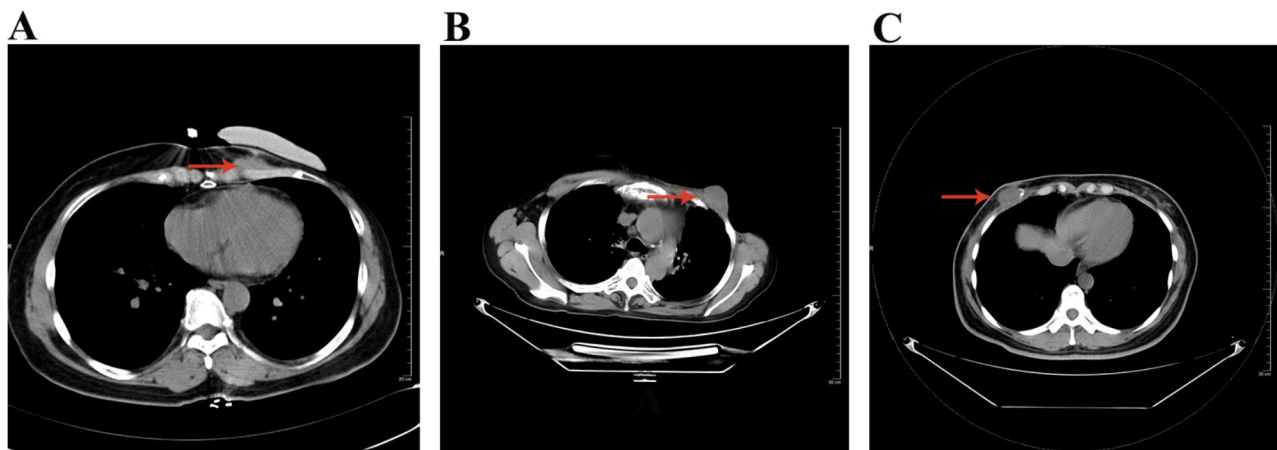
Imaging studies revealed a soft tissue mass (red arrows) corresponding to the palpable lesion on CT Chest. (A) hypoechoic mass subcutaneously on the left chest wall; (B) soft tissue nodular in left chest wall; (C) a mass in the lower quadrant of the right breast
